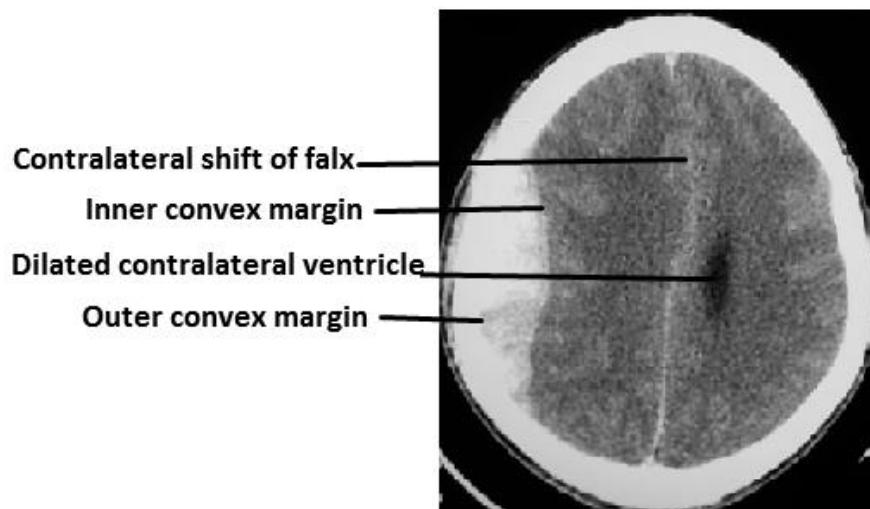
Non-contrast CT image of acute epidural haemorrhage
